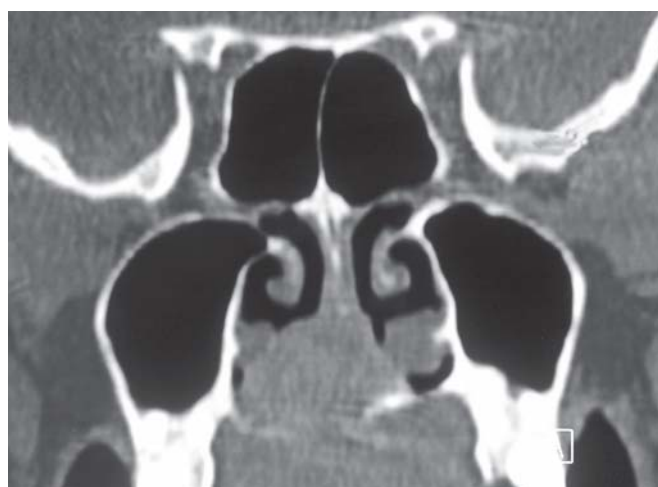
CT scan showing extension of the disease into the nasal cavity
